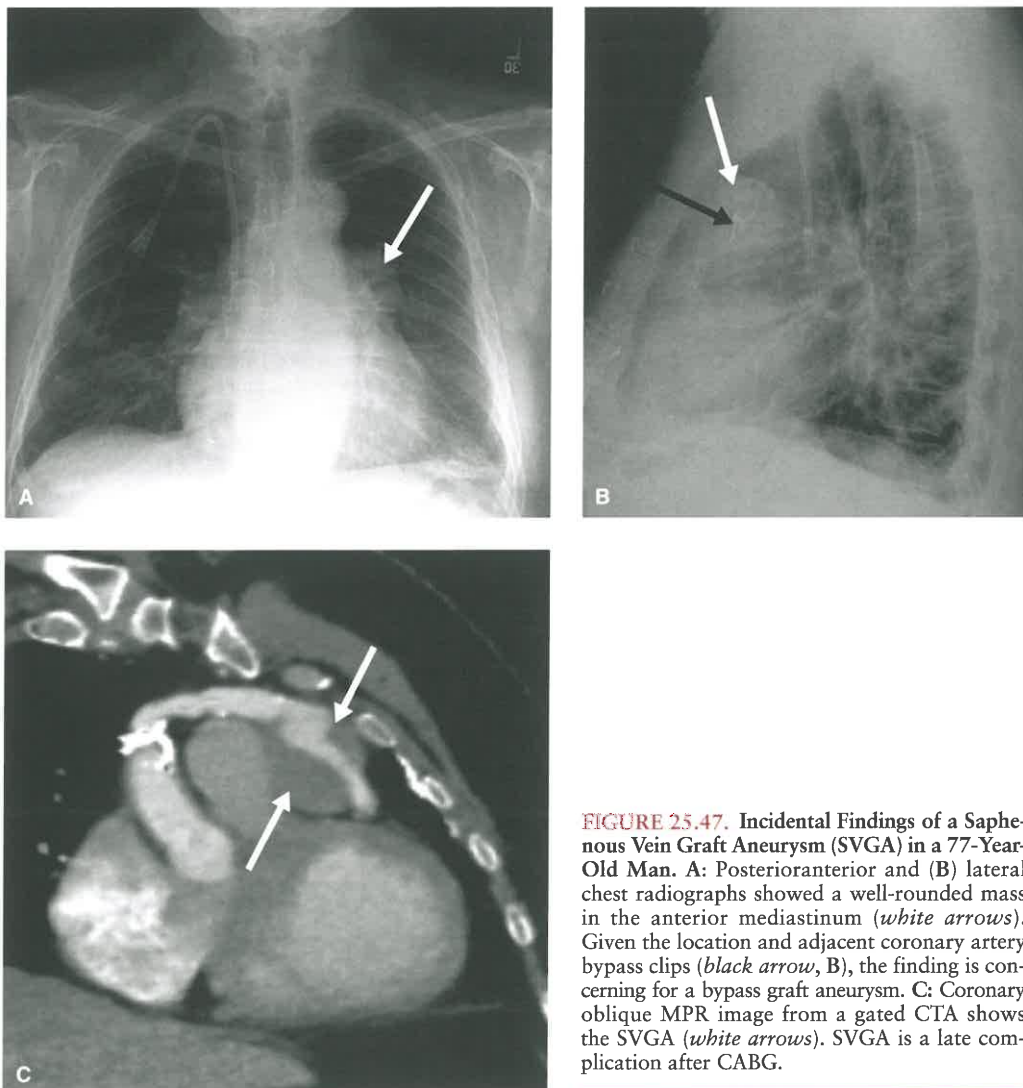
Incidental Findings of a Saphenous Vein Graft Aneurysm (SVGA) in a 77-Year-Old Man. A: Posterioranterior and (B) lateral chest radiographs showed a well-rounded mass in the anterior mediastinum (*white arrows*). Given the location and adjacent coronary artery bypass clips (*black arrow*, B), the finding is concerning for a bypass graft aneurysm. C: Coronary oblique MPR image from a gated CTA shows the SVGA (*white arrows*). SVGA is a late complication after CABG.
